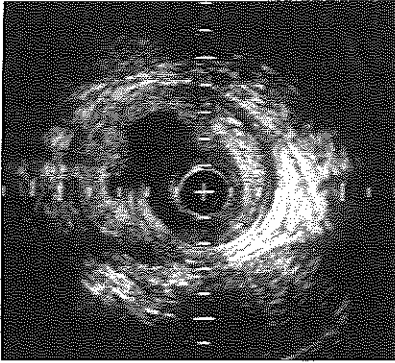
Intravascular ultrasound cross-section of the superficial femoral artery showing the irregular lumen contour following balloon angioplasty. Calibration 1 mm.
